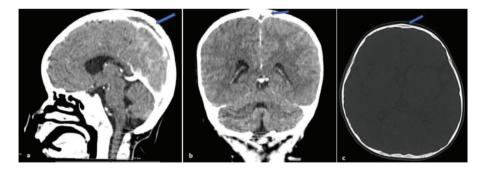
Brain CT with contrast - Superior sagittal sinus thrombosis: a) Sagittal section; b) Coronal section; c) Transverse section.
